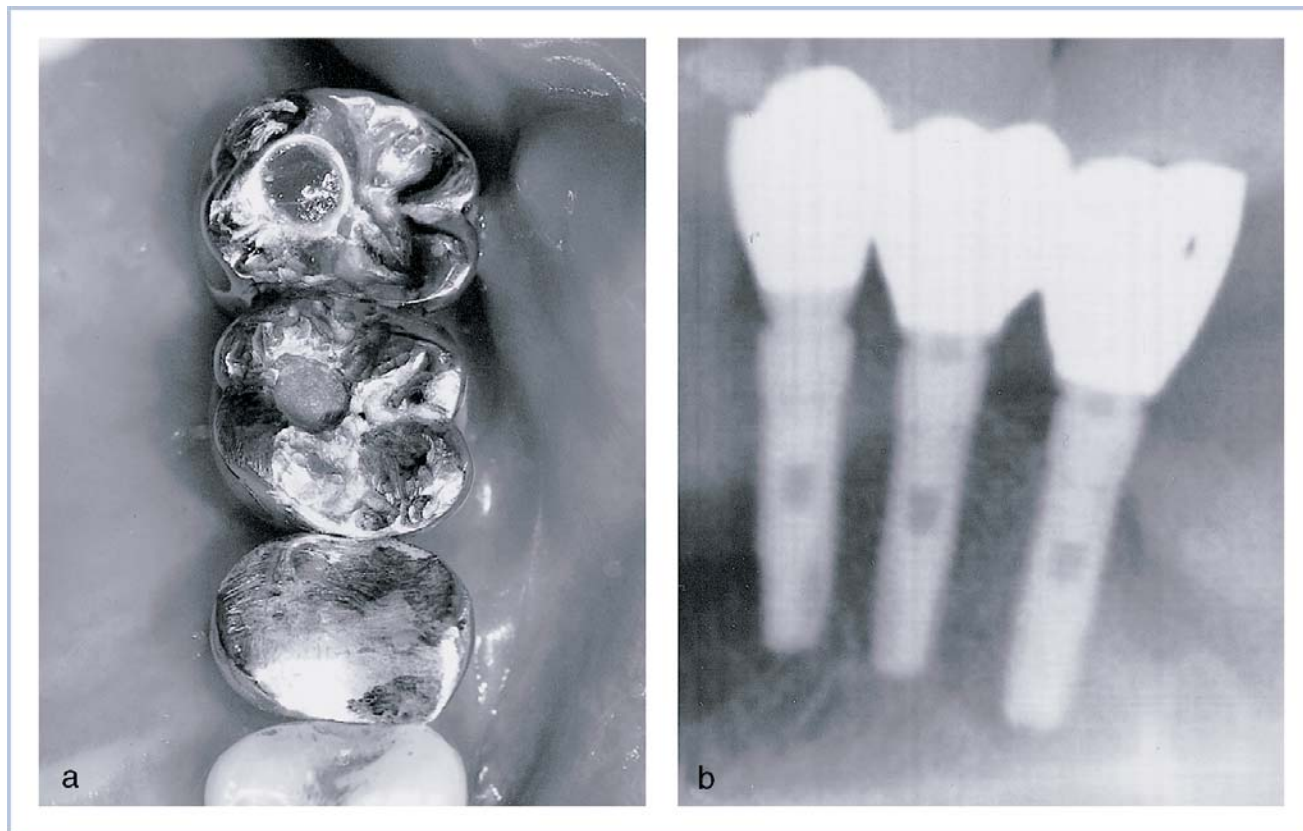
(a) Prosthesis in function after 6 months for upper right 2nd premolar and after 9 months for upper right 1st and 2nd molar. (b) Radiograph showing no specific bone loss around implant.
